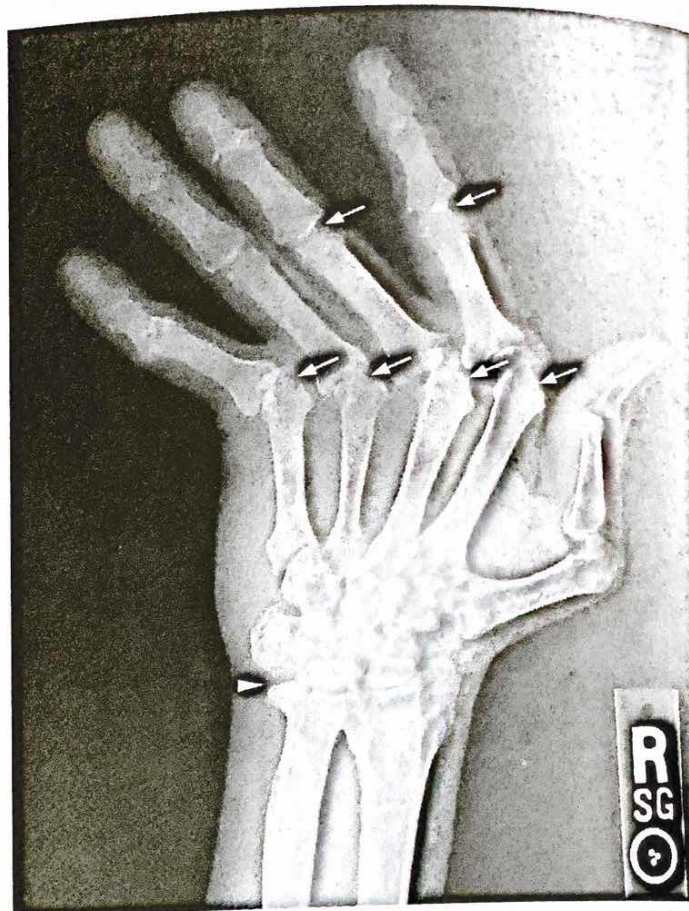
Radiograph showing advanced rheumatoid arthritis in the hand. There is ulnar deviation at the metacarpophalangeal joints; marginal erosions most prominently at the second through fourth metacarpophalangeal joints and the second and third proximal interphalangeal joints (arrows); and joint-space narrowing at the wrist, metacarpophalangeal, and proximal interphalangeal joints, which also represents erosive disease. Note the loss of the ulnar styloid (arrowhead), another common sign of bony erosion in rheumatoid arthritis.
